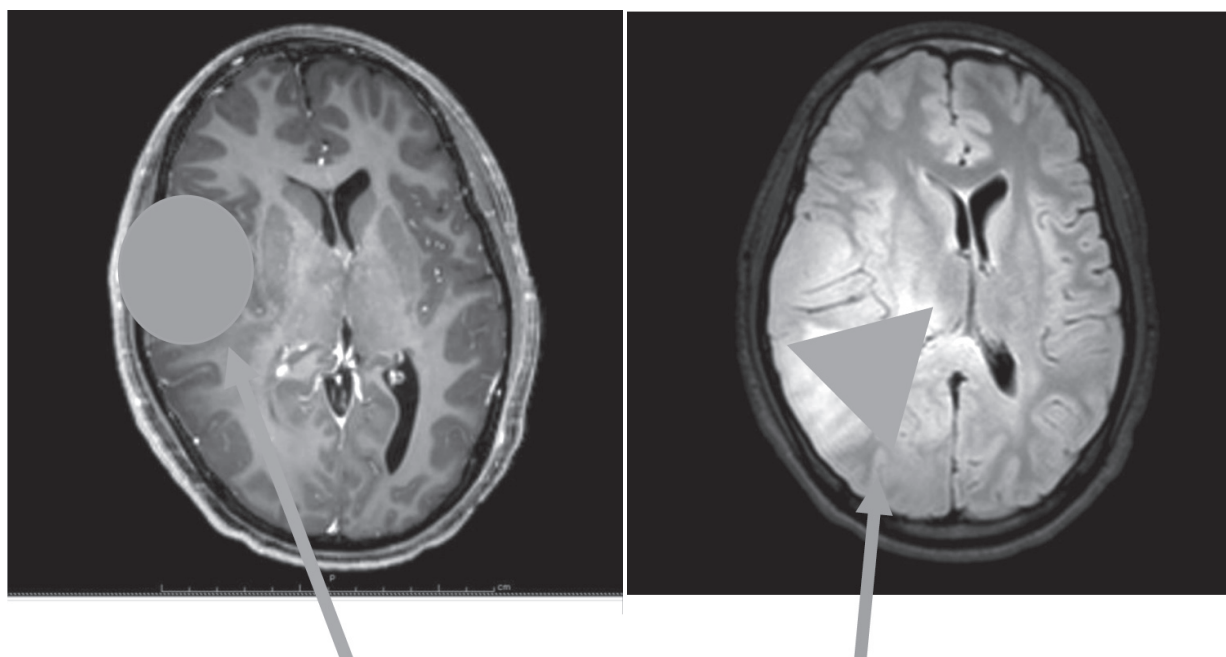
Demonstrate enhancing area (T1w gd) and Non-enhancing edematous area (NEA) (T2 FLAIR).
